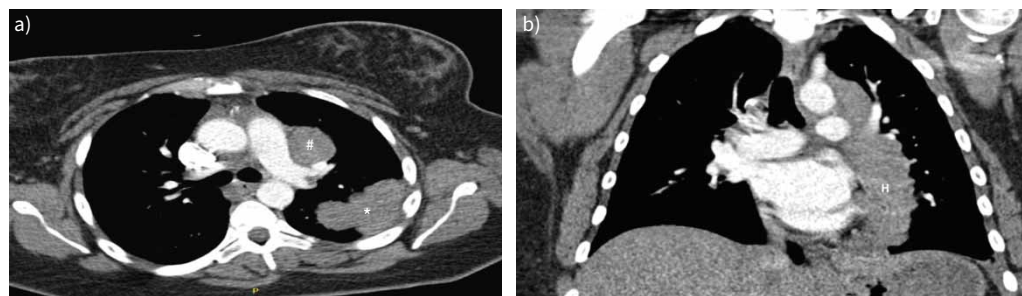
a) CT axial view. b) CT coronal view.
